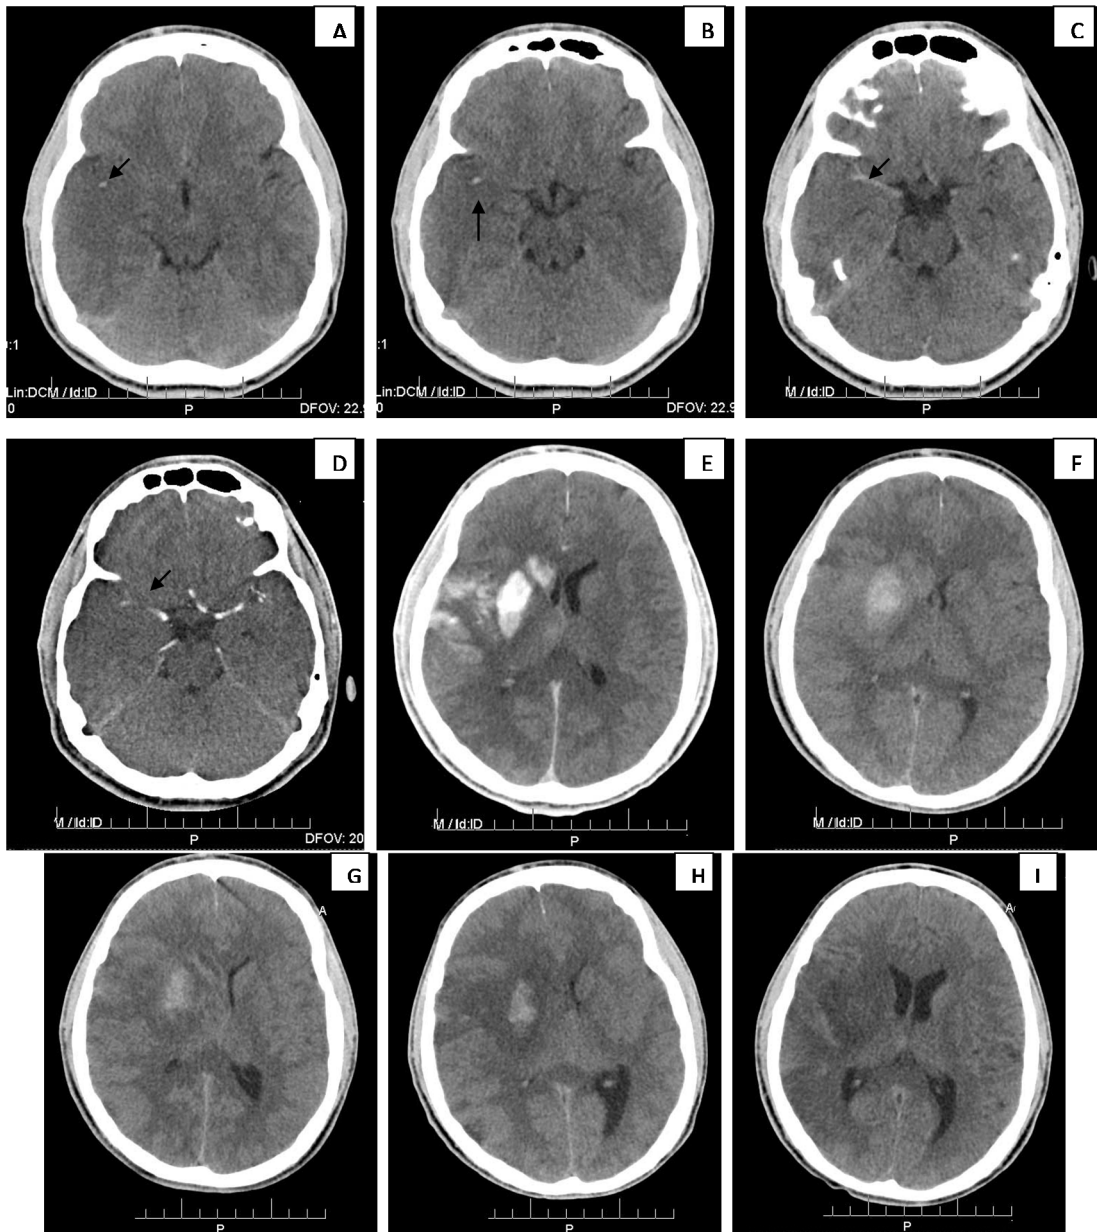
A, B - right M2 thrombus; C- right M2, M1 thrombus; D - angio-CT aspect of M1 thrombus occlusion; E - postoperative CT control; F - 24 h CT control; G - 3 days Ct control; H - 5 days CT control; I - 15 days CT control
